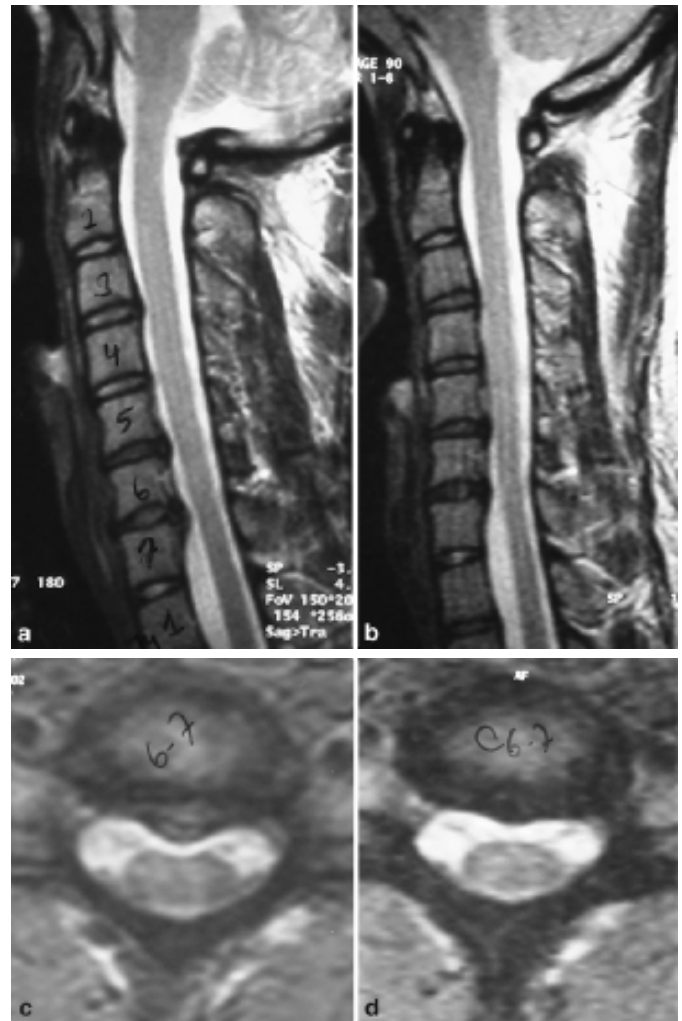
a T<sub>2</sub>-weighted sagittal MRI showing C5–6 extruded disc herniation. b T<sub>1</sub>-weighted sagittal MRI showing spontaneous regression of the C5–6 extruded disc herniation. c T<sub>2</sub>-weighted axial MRI showing C5–6 left posterolateral extruded disc herniation. d T<sub>2</sub>-weighted axial MRI showing spontaneous regression of the C5–6 left posterolateral extruded disc herniation.
